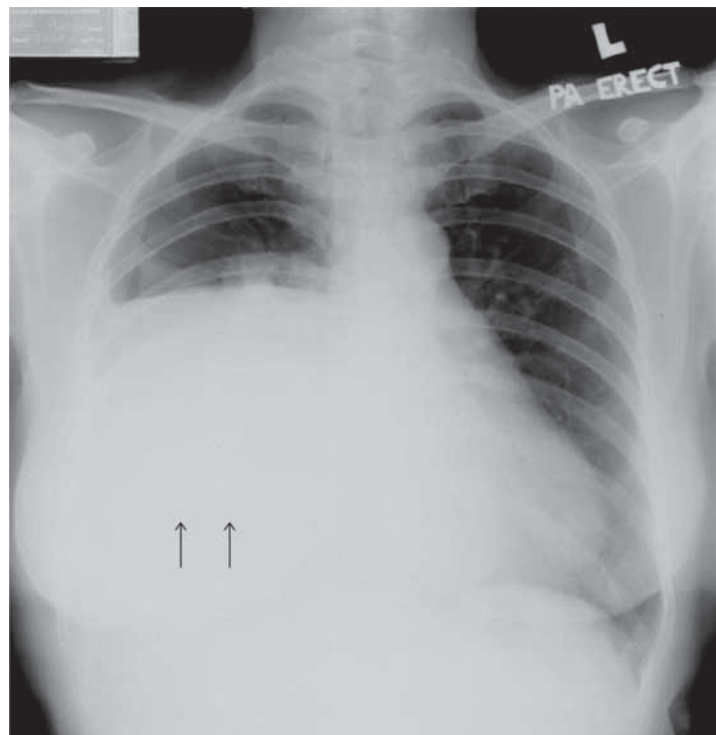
A frontal chest radiograph demonstrating homogenous opacity in the inferior half of the right hemithorax (black arrows), with trachea and mediastinum shift to the contralateral side.
